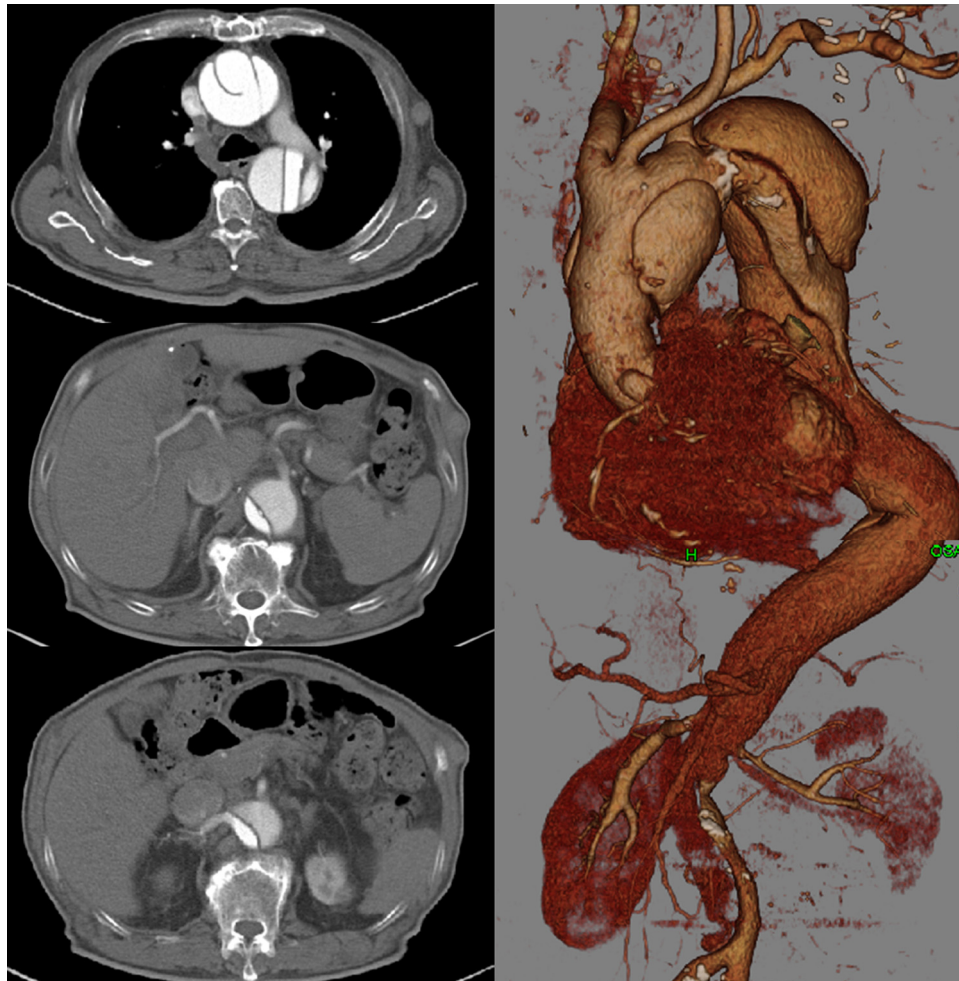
Preoperative CT. The proximal aortic arch was the primary entry site of the false lumen, which extended to the celiac trunk and the origin of the superior mesenteric arteries.
